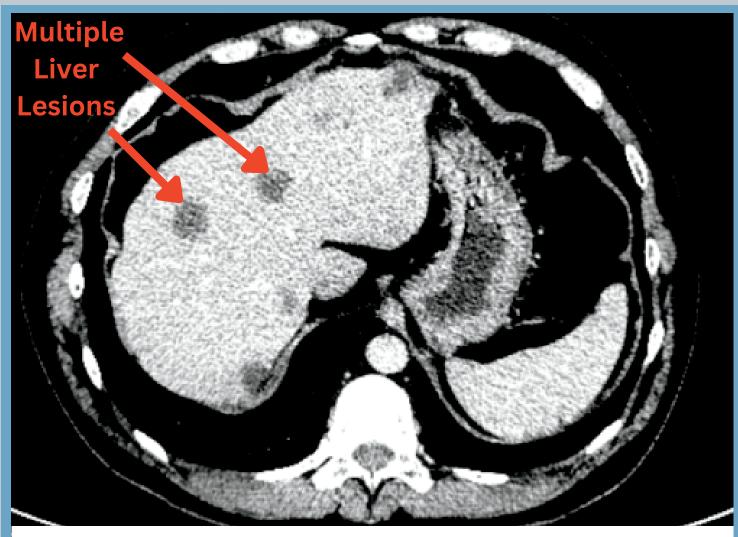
CT/abdomen/pelvis with contrast. Transverse view.
